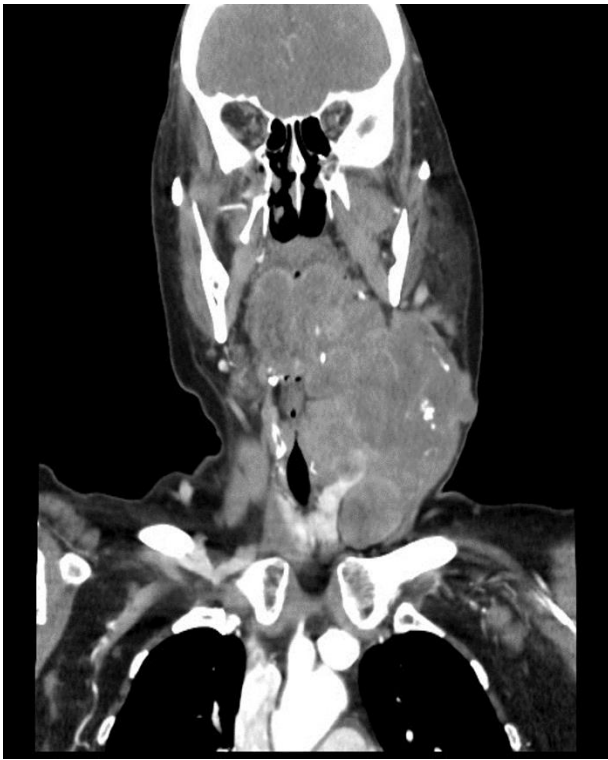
CT Scan with contrast demonstrating Recurrence of Aggressive Fibromatosis
